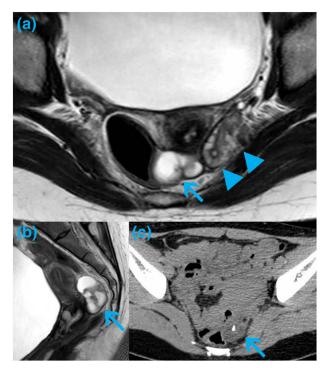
Imaging of teratoma of the fallopian tube. (a) Transverse and (b) sagittal T2-weighted magnetic resonance imaging show the polycystic mass (arrow) beside the ovary (triangle) together with a high-density area of local calcification shown on (c) the computed tomography image.
